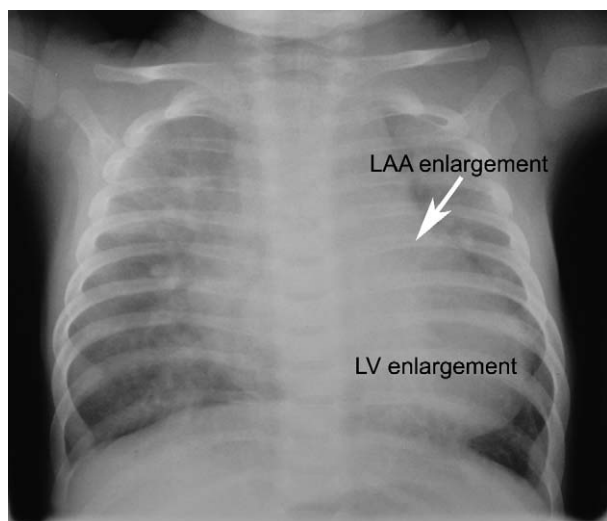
Left atrial (LA) appendage and left ventricular (LV) enlargement with increased pulmonary vascular markings, typical chest X-ray (CXR) findings of a non-restrictive ventral septal defect (VSD).
